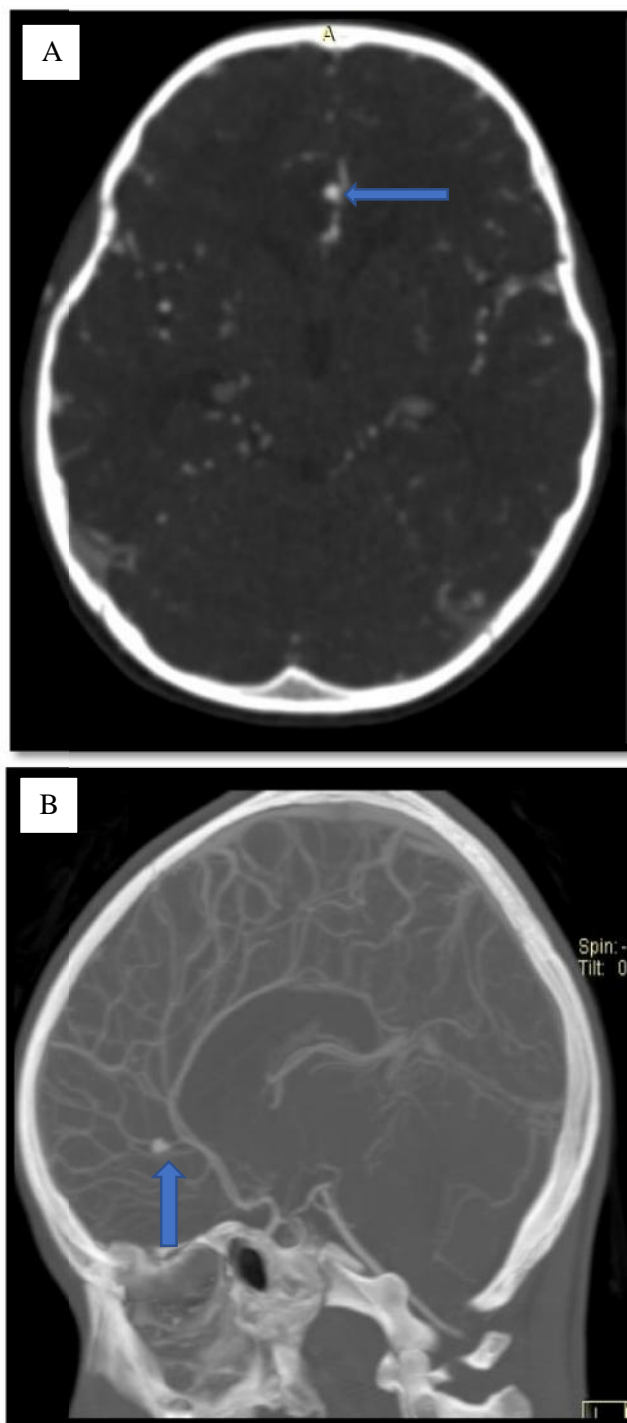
(A) arterial phase axial CTA. (B). Sagittal MIP showing a small saccular aneurysm arising from the pericallosal segment of left ACA.
